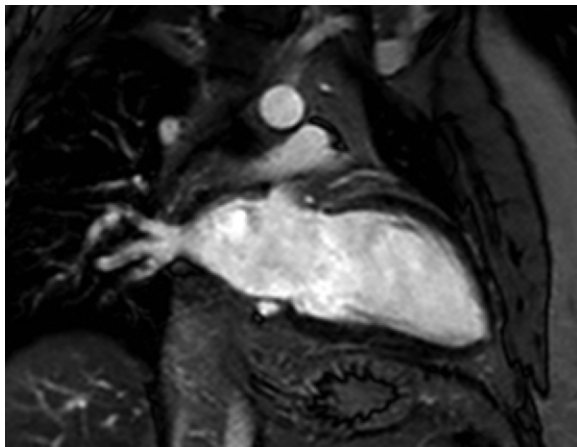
High-quality delayed-enhancement MR image at 3 T shows high SNR and contrast between the nulled myocardium and blood pool.
